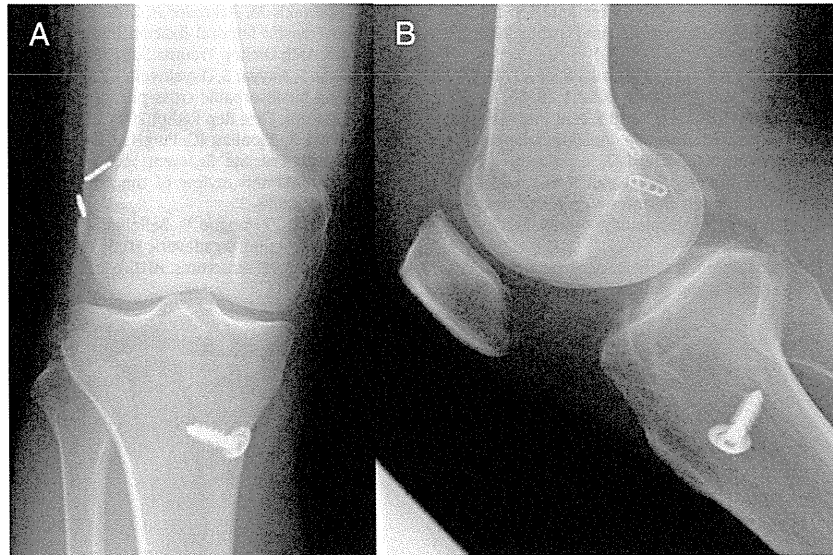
Anteroposterior (A) and lateral (B) radiographs of Case 2 obtained after anatomic anterior cruciate ligament reconstruction showed two EndoButtons. The EndoButtons were in contact with the lateral femoral cortex.
